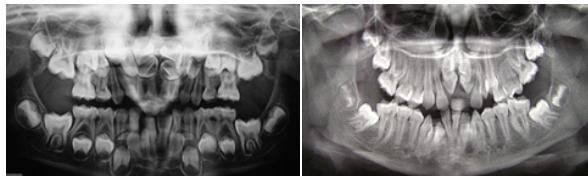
Initial and progress radiographies of case 2
